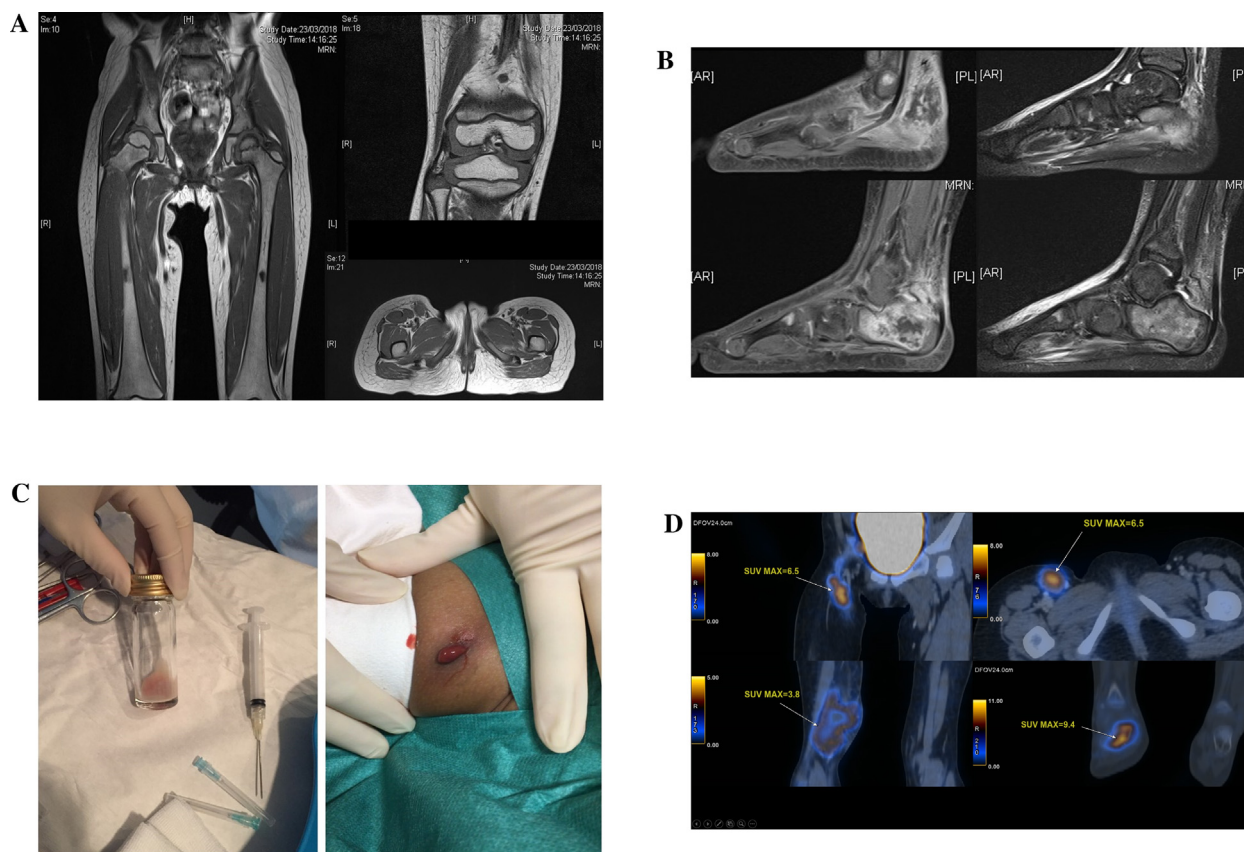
(A) MRI of bilateral hips and thigh showing bilateral shotty groin LNs accompanied with subcutaneous edema over right upper medial thigh and posterior distal thigh. (B) MRI of right ankle showing T1 hypointense and T2 hyperintense signals at right talus, right distal tibia, right third proximal metatarsal, right distal fibula, right calcaneus, and right posterior ankle. (C) Suppurative aspirate obtained by ultrasound-guided aspiration of the right groin abscess. (D) PET-CT 12 days after the first operation showing abscesses in the right posterior thigh and popliteal fossa (SUV_{max} 3.8), right calcaneal osteomyelitis (SUV_{max} 9.4), as well as multiple hypermetabolic LN at the right groin (SUV_{max} 6.5) extending to the right internal iliac LN.
